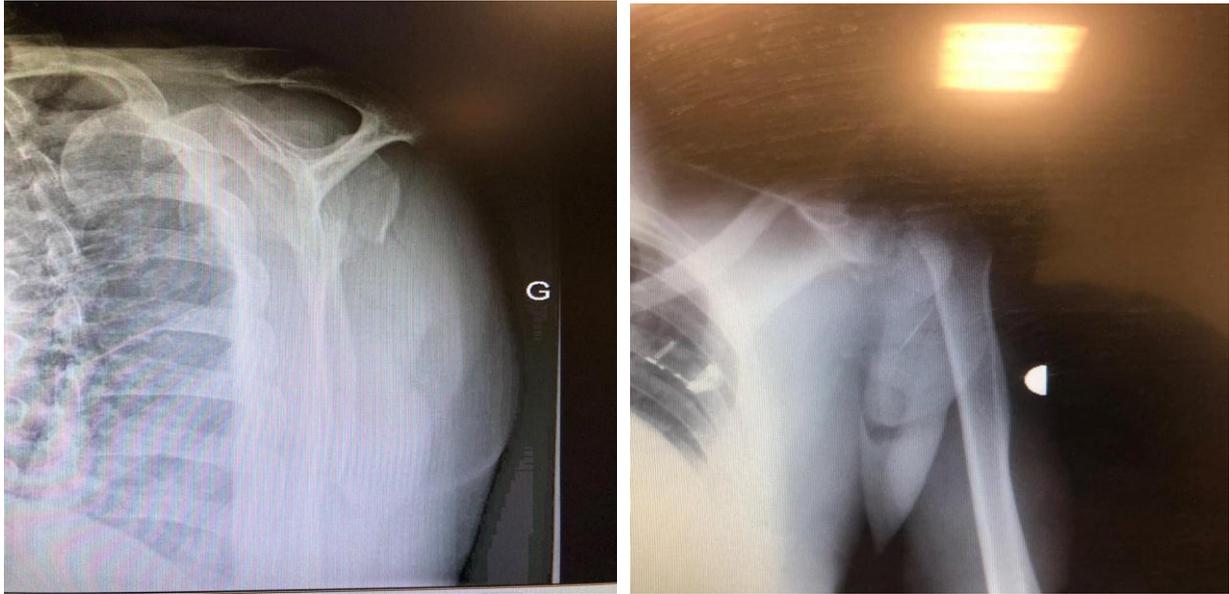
X-ray of the shoulder: comminuted fracture of the upper extremity of the humerus.
